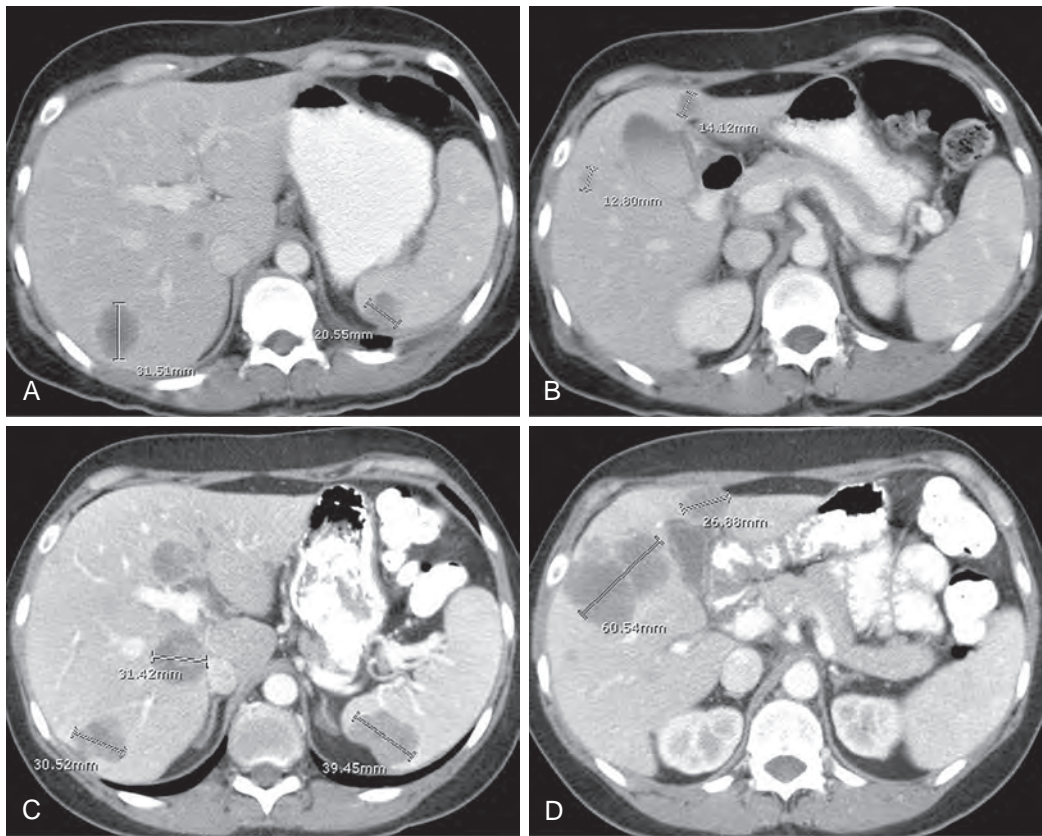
RECIST 1.0. A 39-year-old man with hepatic metastases from colon cancer. Sum of longest diameter of target lesions on initial scan was 77 mm (A and B). On follow-up CT (C and D), there was progressive disease per RECIST 1.1, with sum of longest diameter of target lesions of 238 mm.
